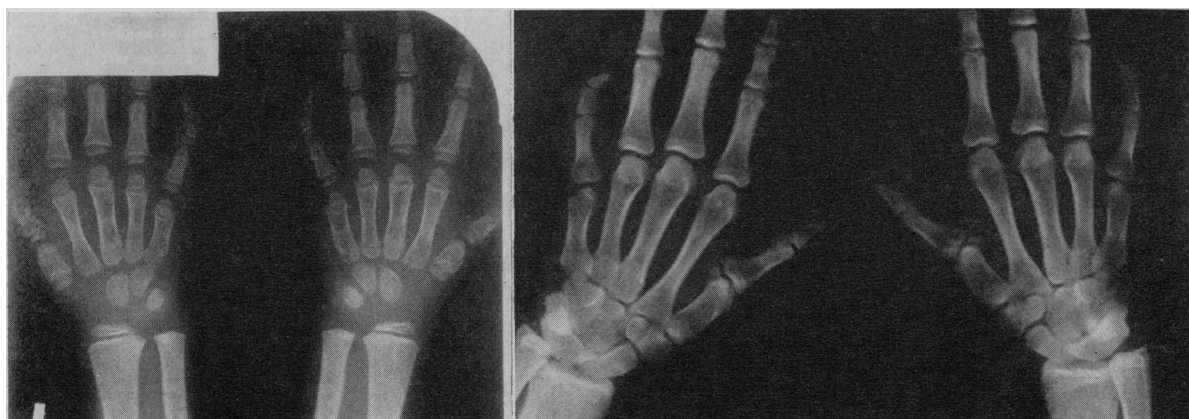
Radiographs of carpal bones of Case 20 at age 7 and 18 years. Bone age grossly retarded at age 7 and normal at 18. Also at age 18 note fusion between trapezium and trapezoid, capitate and hamate and between triquetral and lunate.
